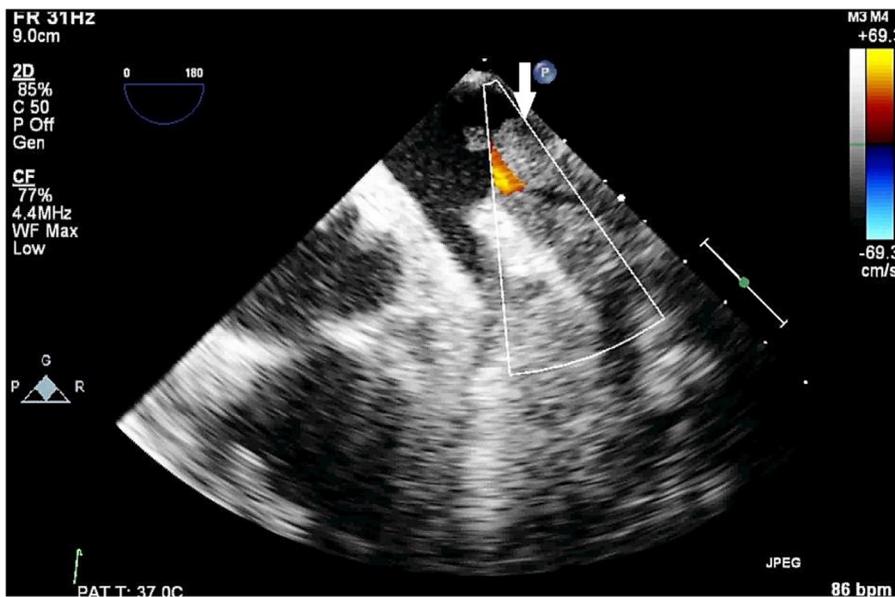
Color Doppler in the same view showing near occlusive nature of the pulmonary vein thrombus.
